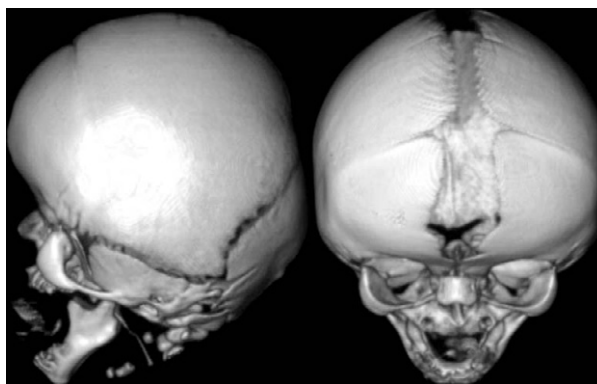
Three-dimensional computed tomography reconstruction of the skull.
